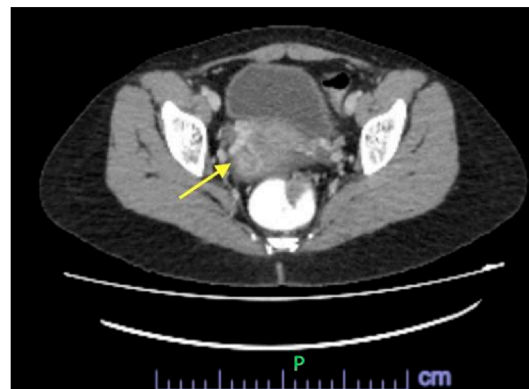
CT scan: There is a heterogeneously enhancing mass within the uterus, measuring $5.4 \times 7.1 \times 5.4$ cm (AP \times W \times CC) (arrow) with surrounding prominent uterine veins. No clear fat plane seen between the uterine mass and the rectum posteriorly and the urinary bladder anteriorly. P represents posterior in an X-ray picture.
